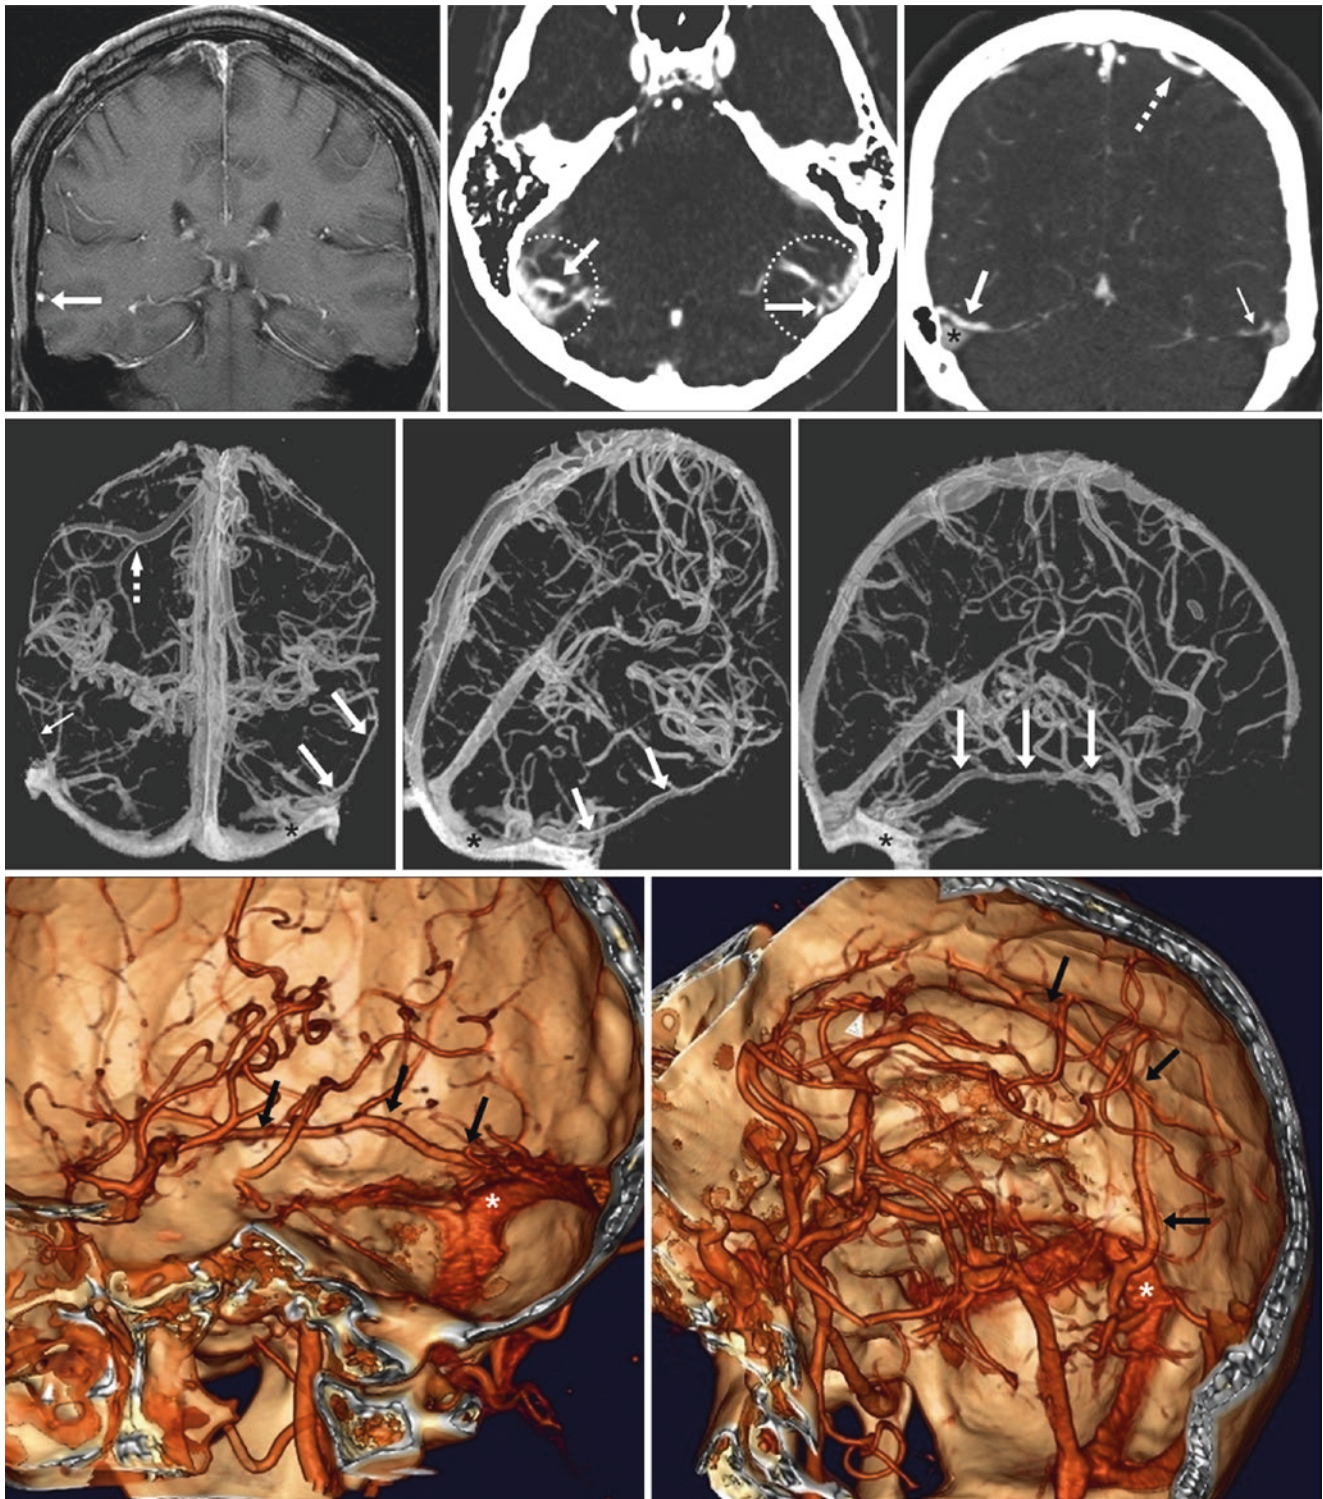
45-year-old with pain (negative study). *Top row:* A prominent right VOL (arrow) is seen on coronal postcontrast T1WI MRI (left). CTV 7 mm thickness axial (middle) and coronal (right) MPRs demonstrate that the right VOL courses through the LTS (bilaterally outlined by dotted circles) to connect to the transverse sinus (asterisk). There is a tiny left VOL (thin arrow), with a larger, dominant VOT (dotted arrows). *Middle row:* 3D “see through” images in PA-superior
